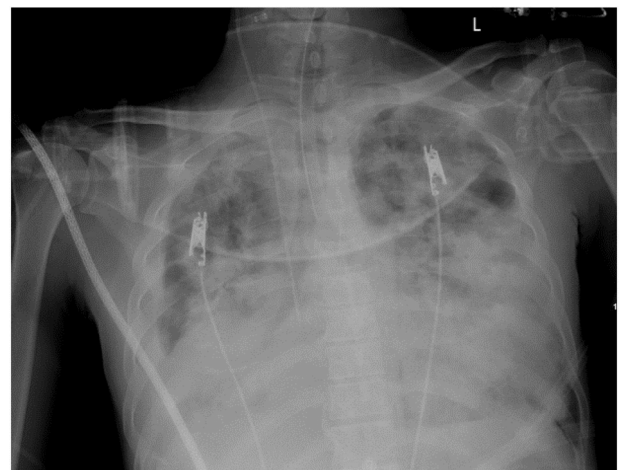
X-ray chest showing bilateral diffuse patchy infiltrates consistent with ARDS.
